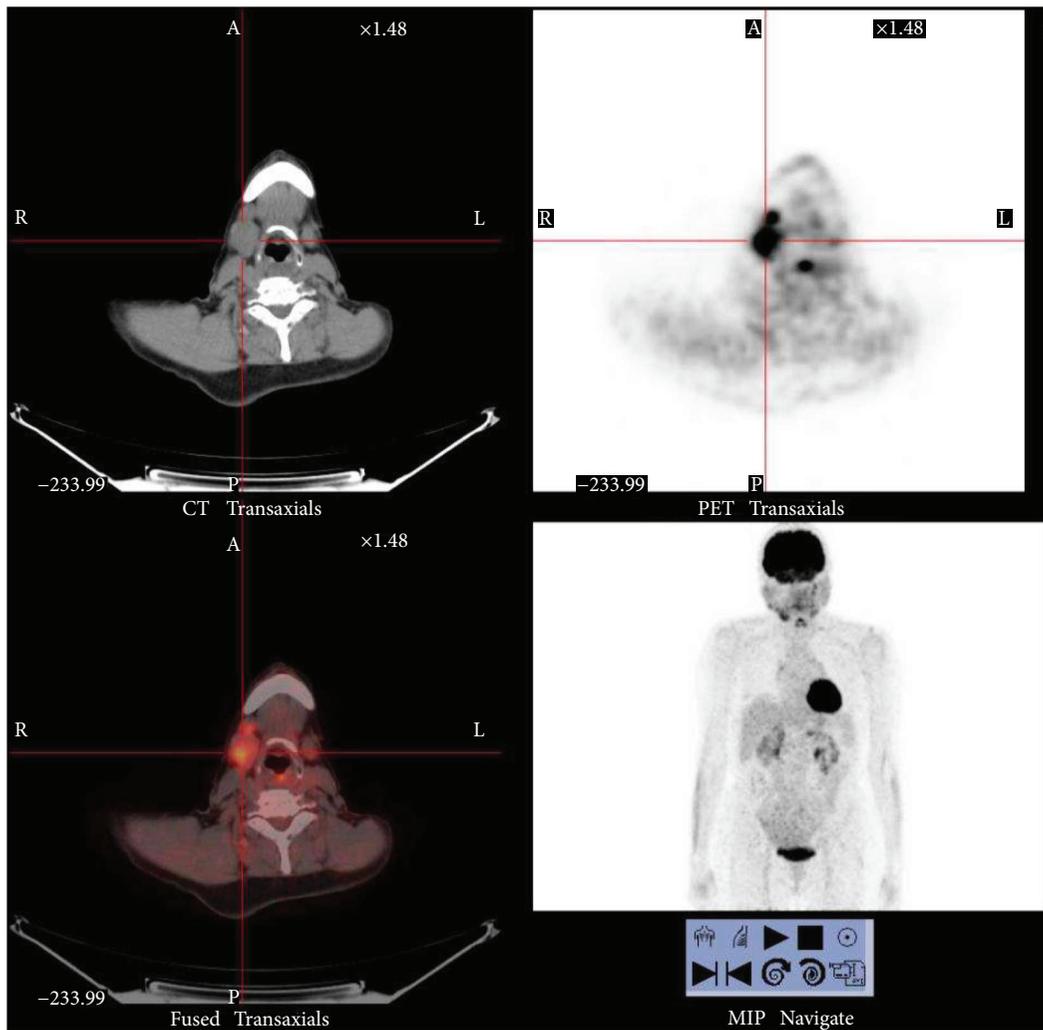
Positron emission tomography (PET) in an IgG4-RD patient with dacryoadenitis and sialoadenitis. PET analysis was performed during relapse of the disease before starting new therapy. In the right submandibular region and pretracheal lymph nodes, the PET analysis shows an enlargement of the parotid gland with an increase concentration of 18-FDG and glucidic hypermetabolism.
